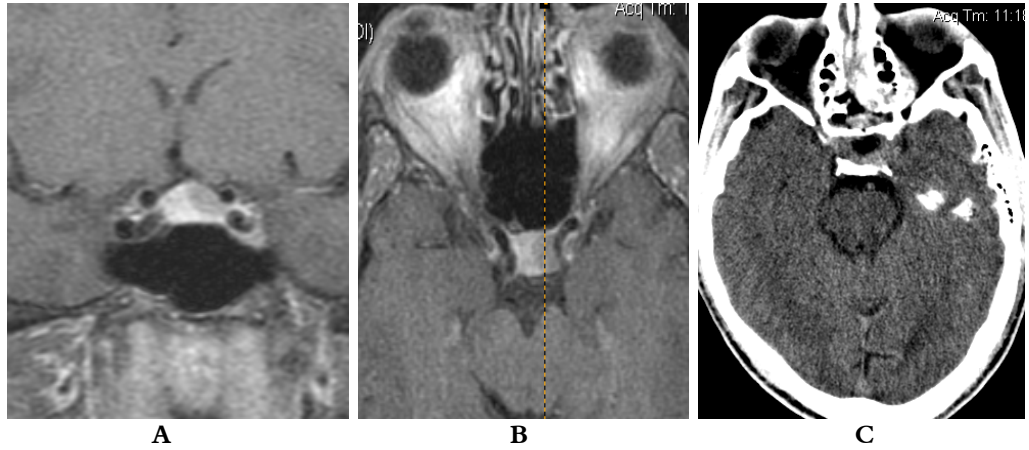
T1 contrast enhanced IRM coronal A and axial B sections showing a hypo intense, non enhancing lesion, in the left pituitary gland C CT scan in the 1st day after transsphenoidal surgery in a 60 y o female with acromegaly and GH $47.8\mu\text{g/L}$
